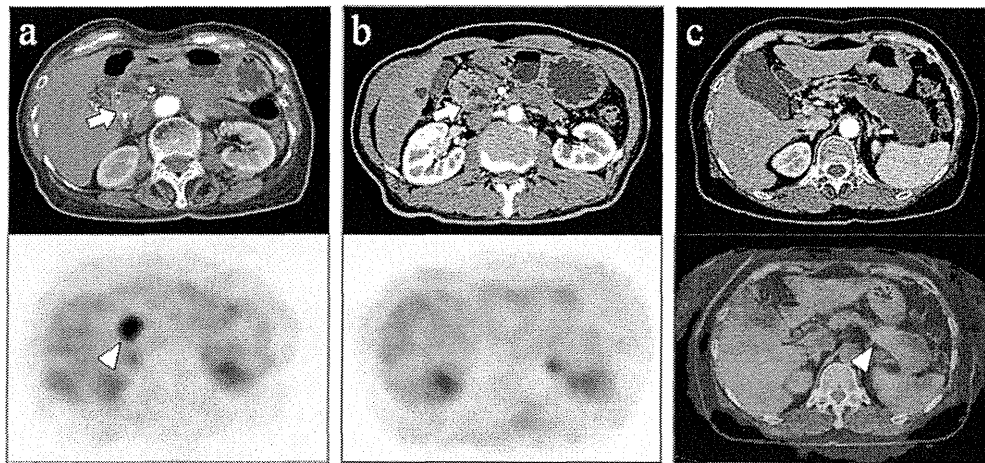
CT and FDG-PET findings of three representative cases [(A) malignant IPMN, (B) benign IPMN, (C) malignant IPMN]. Arrows, mural nodules on CT; arrowheads, the most intense area of FDG accumulation on PET. For abbreviations, see Fig. 1. CT, computed tomography.
